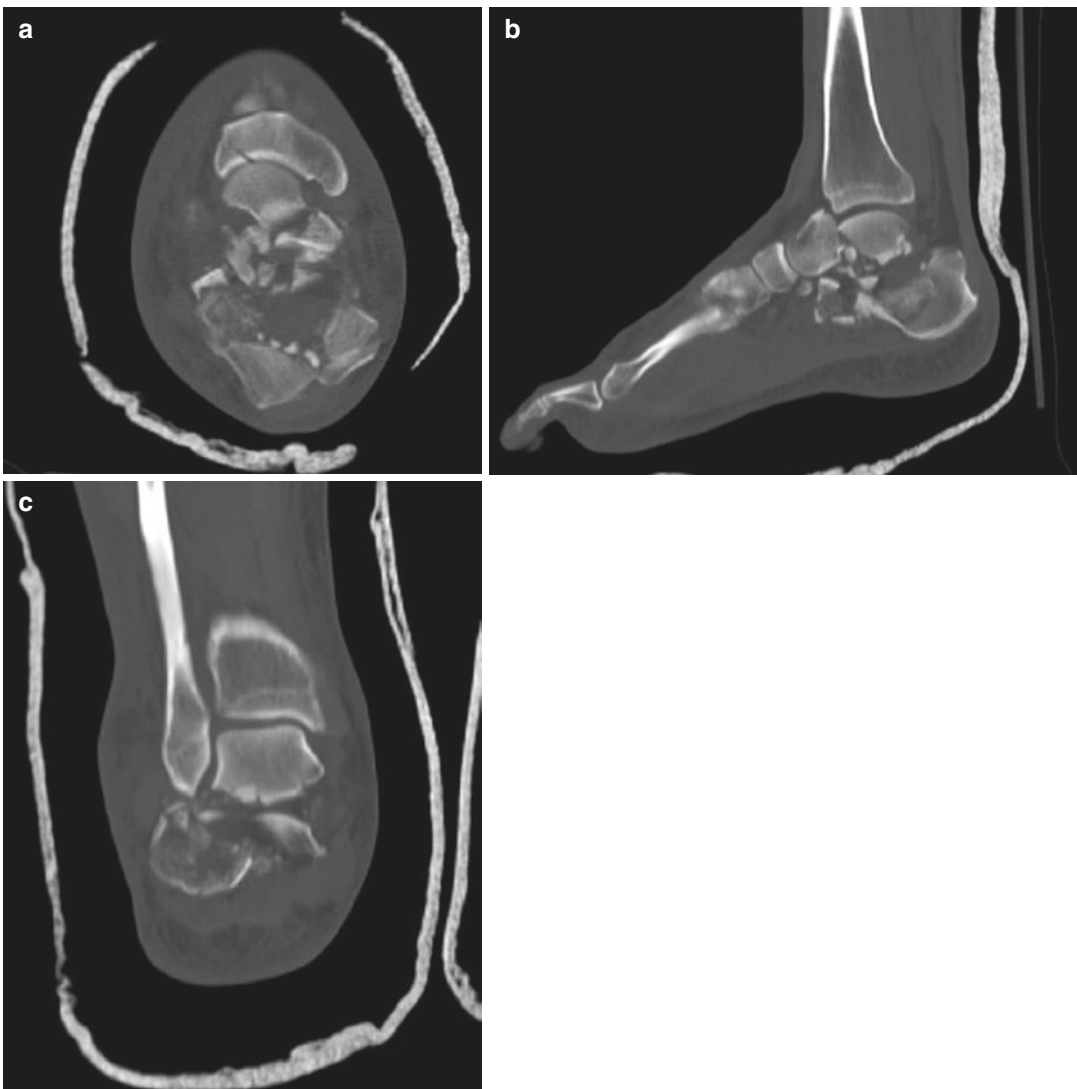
Axial (a), sagittal (b), and coronal (c) CT scan of a combined injury where the posterior facet of the calcaneus is determined not to be reconstructible. Based on imaging, ORIF calcaneus and subtalar arthrodesis is planned
